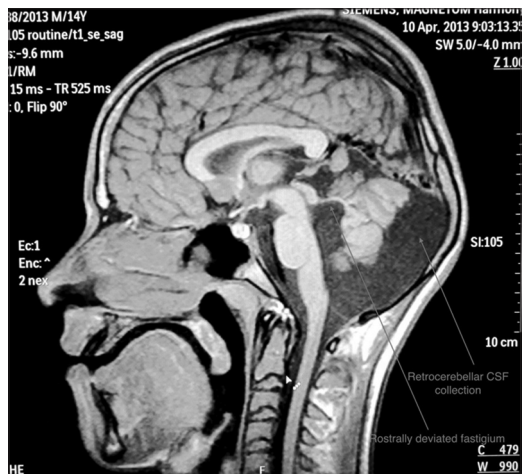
Sagittal T1-weighted image showing the rostrally deviated fastigium and a retrocerebellar cerebrospinal fluid collection
